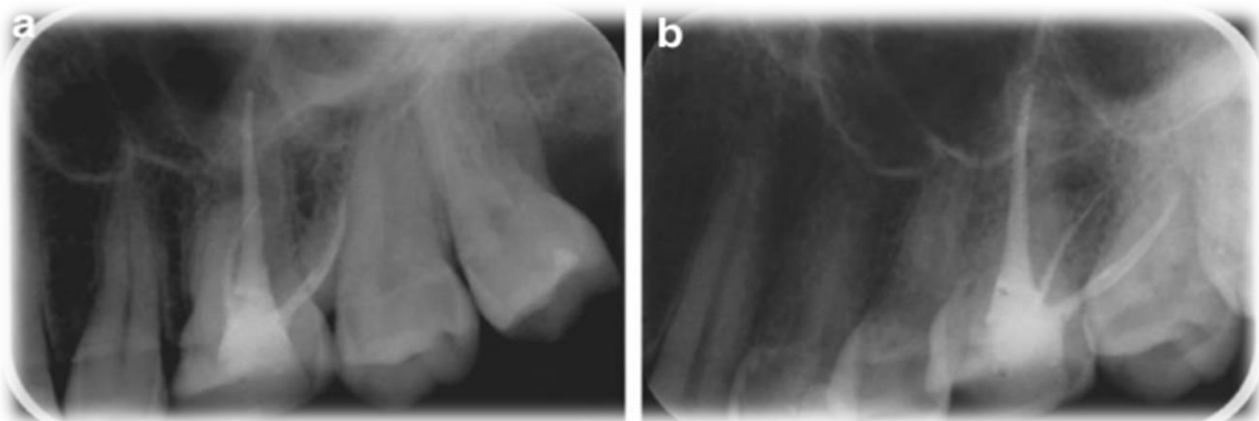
An upper molar with asymptomatic apical periodontitis, A- The radiographs show a periapical radiolucency and fractured instrument in the apical third of the mesiobuccal root. b- With mesial eccentric radiographs, the root-filled canal in the mesiobuccal root moves from the X-rays, not centralized in the canal, indicating a second untreated canal.
